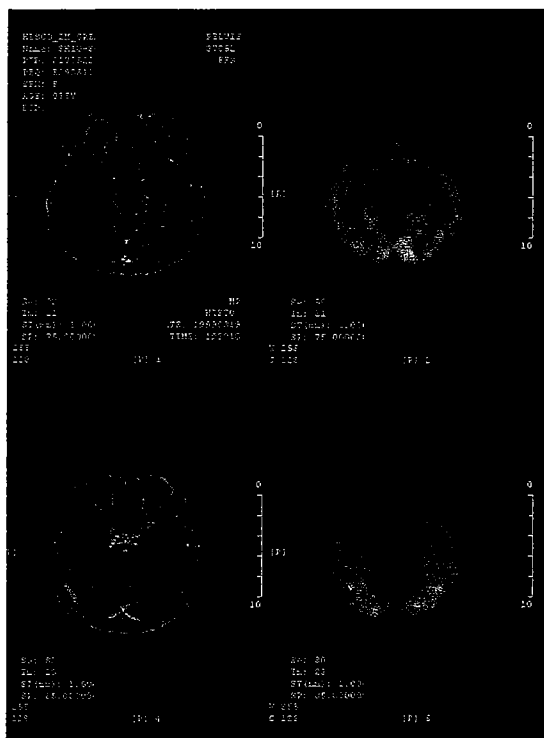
DICOM fusion images being viewed in our PACS viewer (TEDPC SmartView). Through the registration and fusion process, the spatial orientation and resolution are the same for the two series of created DICOM PET and MR images.
